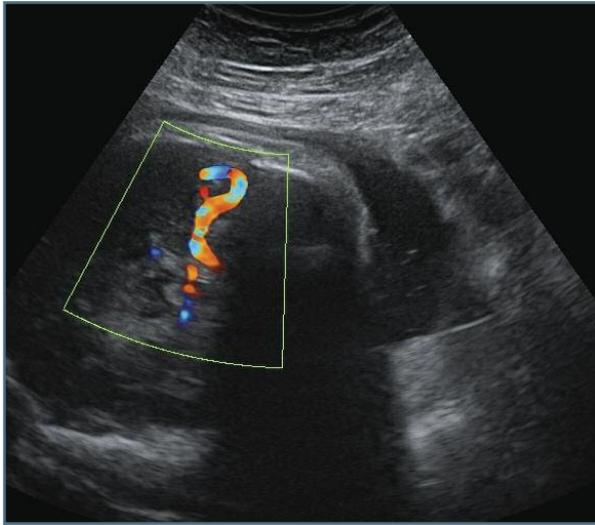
Obstetric sonographic examination at 36 weeks gestation, demonstrating an intracranial high-flow pial AVF using color Doppler
